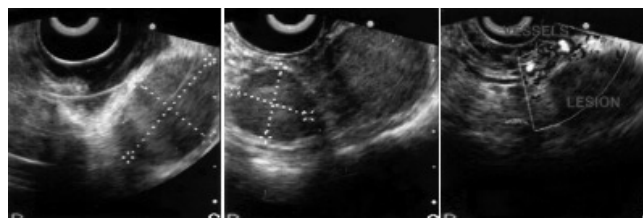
Endoscopic ultrasonography (EUS) showing a hypoechoic bilobular lesion located in the proper muscle layer of the gastric fundus, suggesting GIST. The color Doppler vascular analysis color shows the presence of large vessels above the tumor
